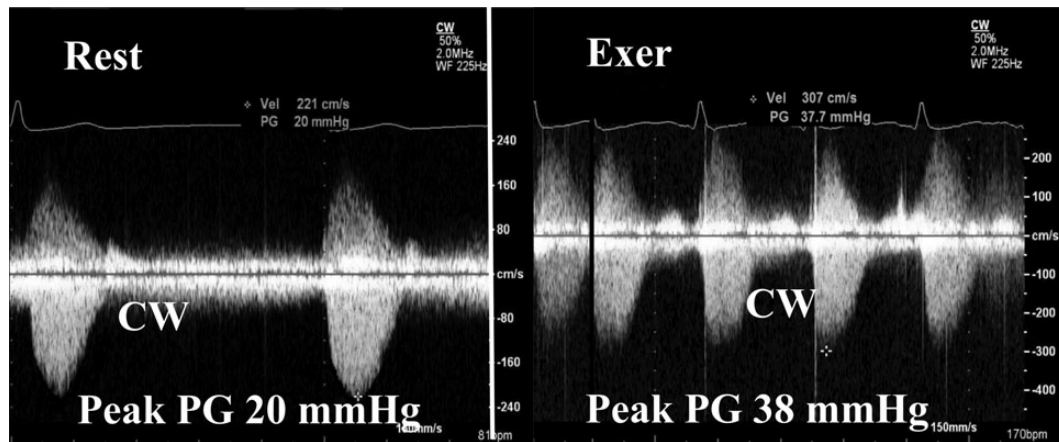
Stress continuous wave (CW) Doppler echocardiography in a 14-year-old patient with residual aortic coarctation post repair. A pre-exercise CW Doppler tracing obtained (left panel) displays a mildly increased resting velocity. At maximum exercise, the peak velocity obtained (right panel) increases slightly demonstrating no significant obstruction. PG, pressure gradient.
